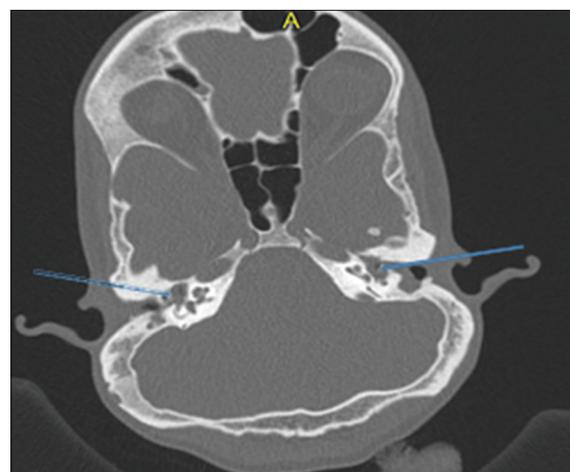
Axial sections of HRCT temporal bone showing bilateral cholesteatoma: Soft-tissue opacification of bilateral middle ear cavity (blue arrows) and mastoid air cells with near complete erosion of ear ossicles
